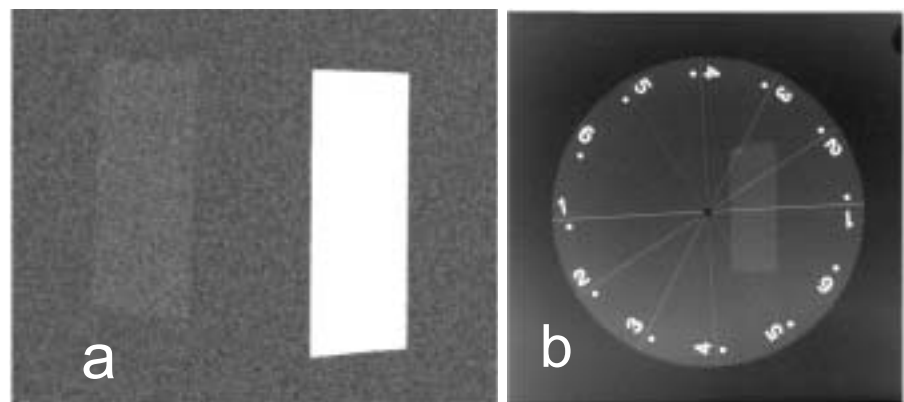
X-ray attenuation of the Al and Cu strip, placed directly onto the x-ray detector (a) and onto a 20 cm Lucite layer (b).
